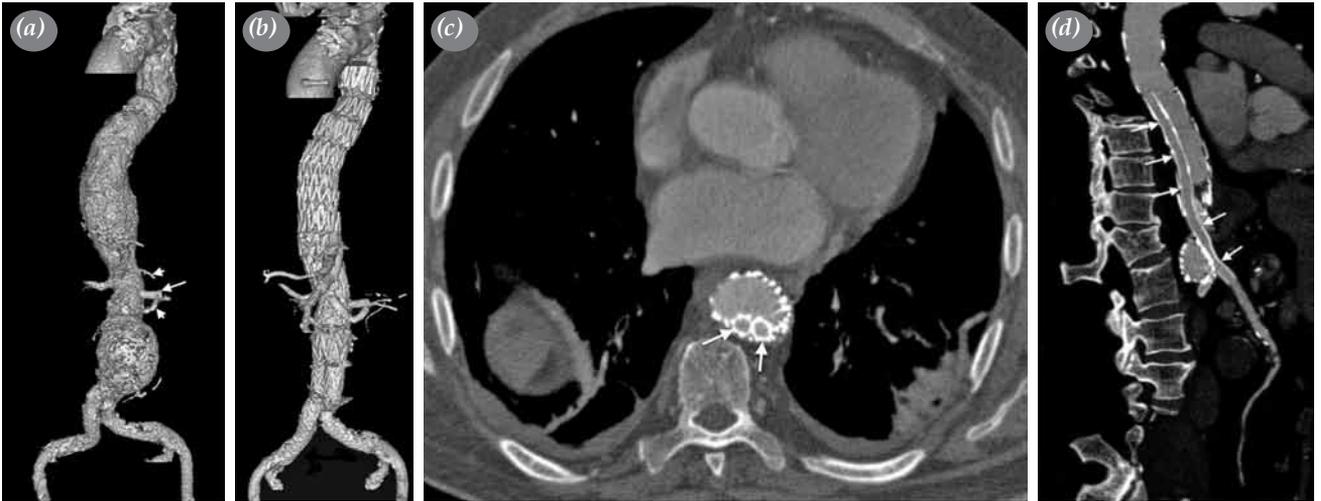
A preoperative volume-rendered three-dimensional reconstruction image (a) showing type-V thoracoabdominal aortic aneurysm including celiac and superior mesenteric arteries and infrarenal abdominal aortic aneurysm. While occlusion of the left main renal artery placed previously stent (arrow) is observed, two left accessory renal arteries (arrowheads) and the right renal artery are patent. A volume-rendered three-dimensional reconstruction image obtained one year after the procedure (b) showing that all implanted stents including aortic endografts and parallel stents are patent. An axial computed tomography angiography image (c) showing patent sandwich grafts (arrows) of celiac and superior mesenteric arteries at the descending thoracic aorta level. A curved multi-planar reformat image (d) showing lengthwise patency of the sandwich graft (arrows) and its continuity with superior mesenteric artery.
